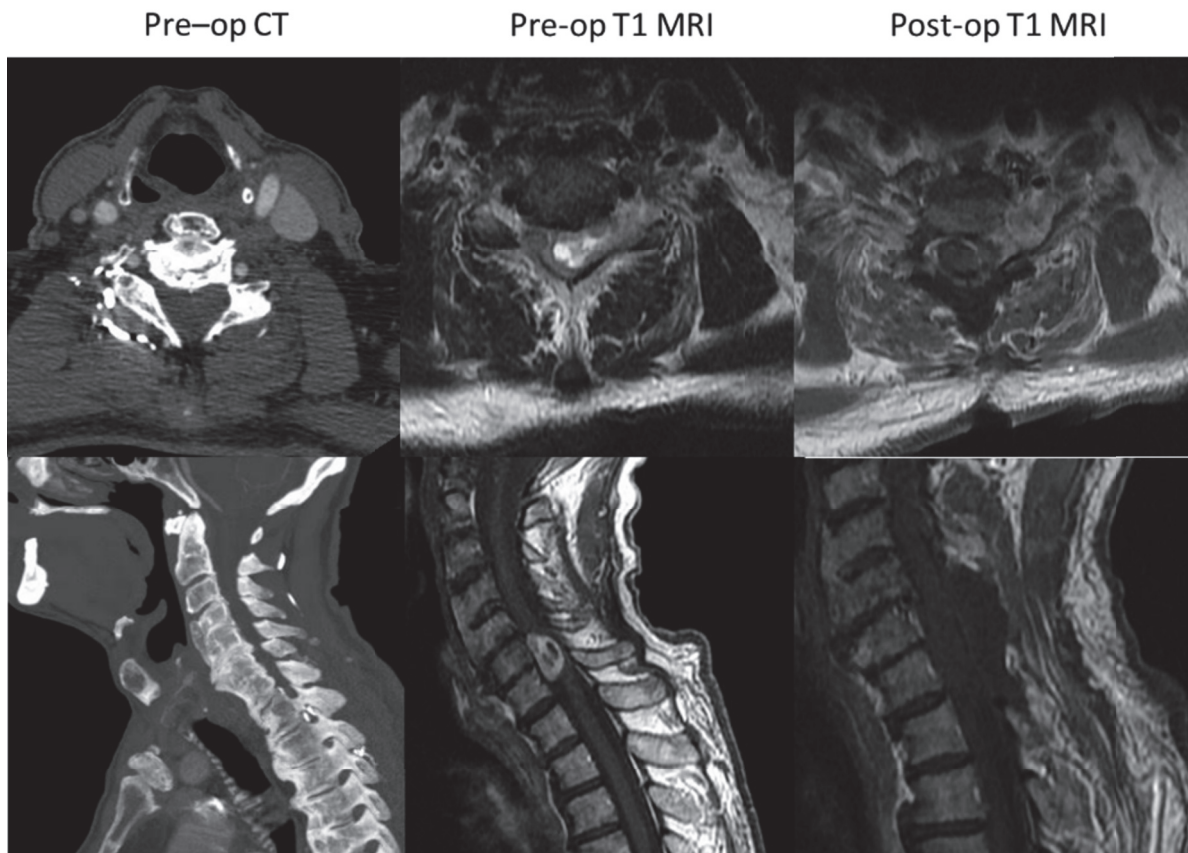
Patient 3: Clinical course – Patient with C6-C7 intradural, extramedullary mass occupying the spinal canal, extending into the epidural space and causing severe rightward displacement and compression of the spinal cord. Visualized on CT angiogram and T1 MRI. Postoperative debulking seen on T1 MRI.
